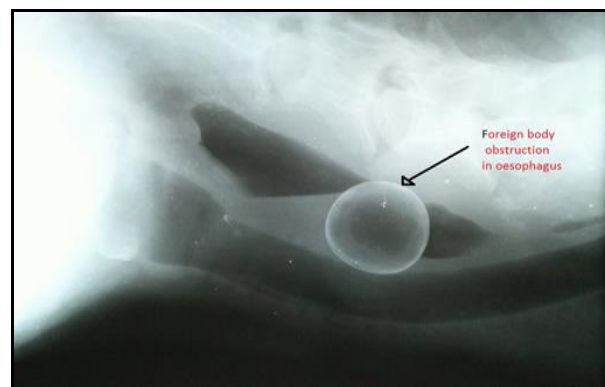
Radiographic finding of obstruction at the cervical part of the oesophagus
